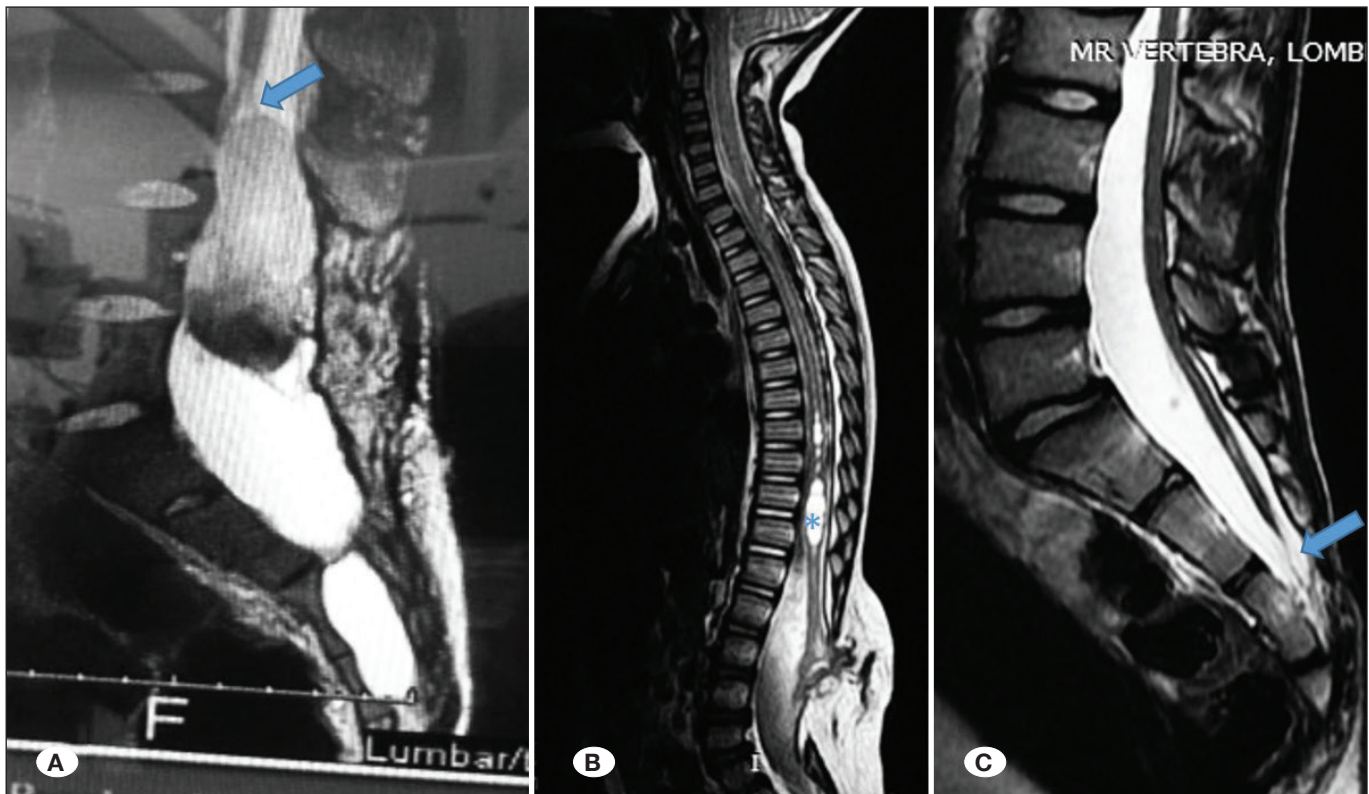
A) T2-weighted images shows an intradural dermoid cyst at L3-4 levels and tethered cord sticking to cyst (arrow); B) T1-weighted sagittal MRI revealed an appearance compatible with tethered spinal cord and syringomyelia (asterix) secondary to lipomeningomyelocele. C) In the T2-weighted sagittal MRI section, fatty filum terminale ending at the S3 level is observed (arrow)
